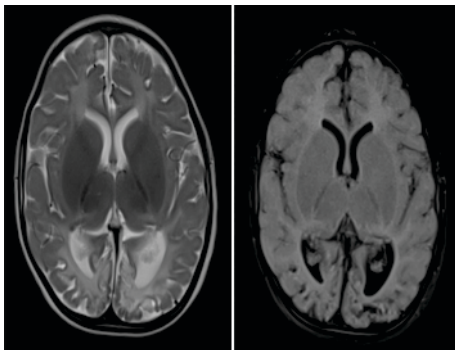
MRI T2 and FLAIR axial images Volume loss with cystic encephalomalacic changes in bilateral parietal and occipital lobes. Confluent T2W/FLAIR white hyperintensities in all visualised lobes - S/o delayed myelination.
